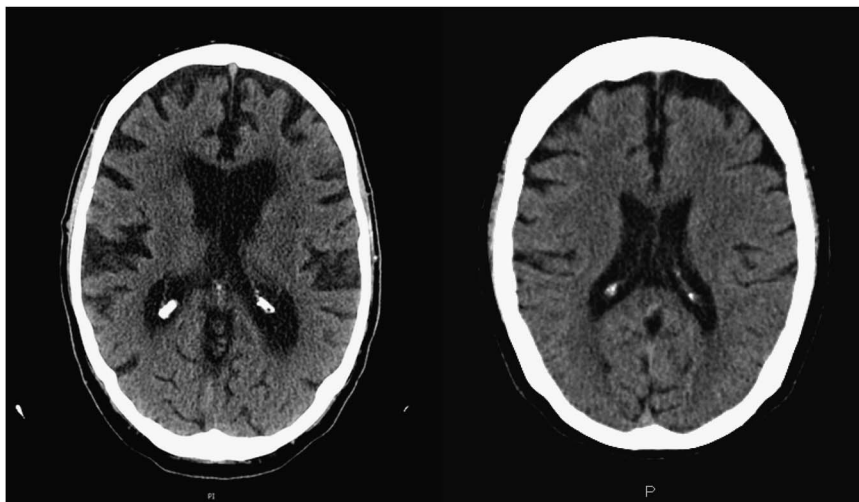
Mid-axial brain CT for Patient 1 (left) and Patient 2 (right).
